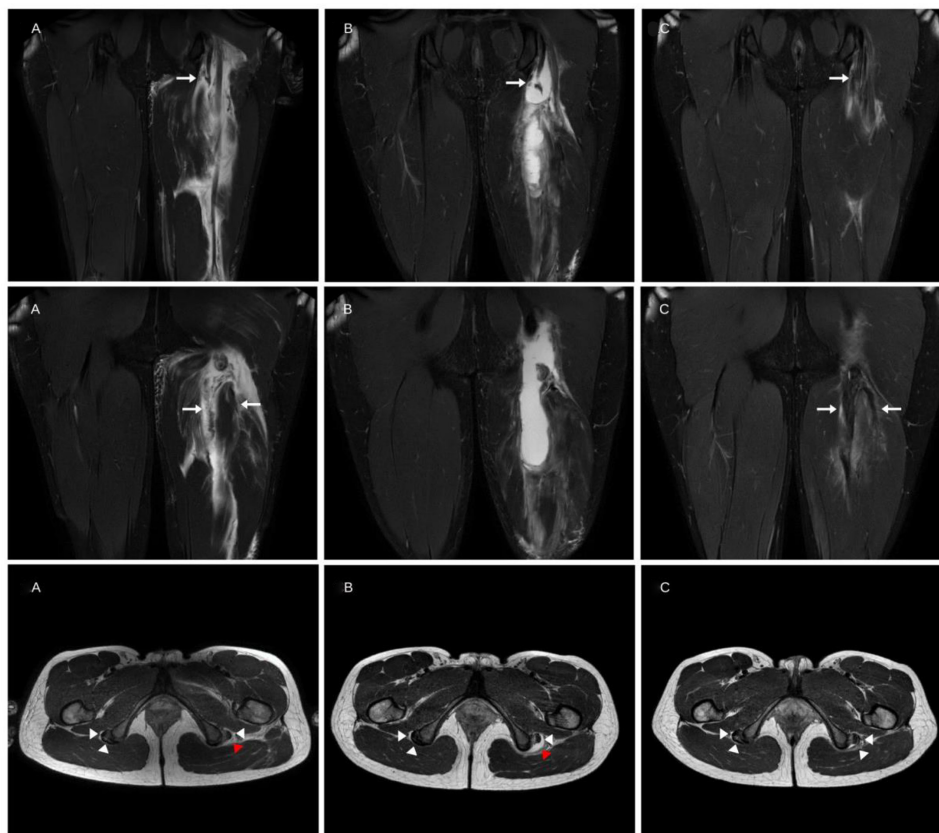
MRI series of an elite athlete. In the coronal series (1A/B/C) the healing process of a full-thickness injury of the free tendon of the semimembranosus muscle is displayed. Over time, a decrease in seroma/haematoma is seen in combination with forming proximal continuity indicated by the white arrow in 1C. In the second coronal series (2A/B/C) the healing process of the conjoint tendon of the long head of the biceps femoris and the semitendinosus is displayed. In 2A there is waviness of both the biceps femoris and the semitendinosus tendon, which is a sign of loss of tension suggesting a full-thickness disruption of the tendons. Over time there is formation of fibrotic tissue in the haematoma/seroma wall. In 2C tendon thickening and reduction of waviness are displayed as signs of tendon healing and recovery of tension. Furthermore, in the axial series (3A/B/C) the healing process of the full-thickness injury of the conjoint tendon is shown. In 3A and 3B, the white arrows show continuity of the tendons, the red arrows indicate the loss of proximal continuity of the conjoint tendon at the ischial tuberosity. In 3C the growth of a neotendon, adjacent to the semimembranosus tendon, is displayed.
